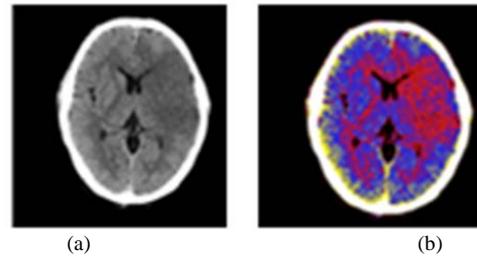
A slice of brain CT image with early infarct using (a) Default method (b) Colorization method.
